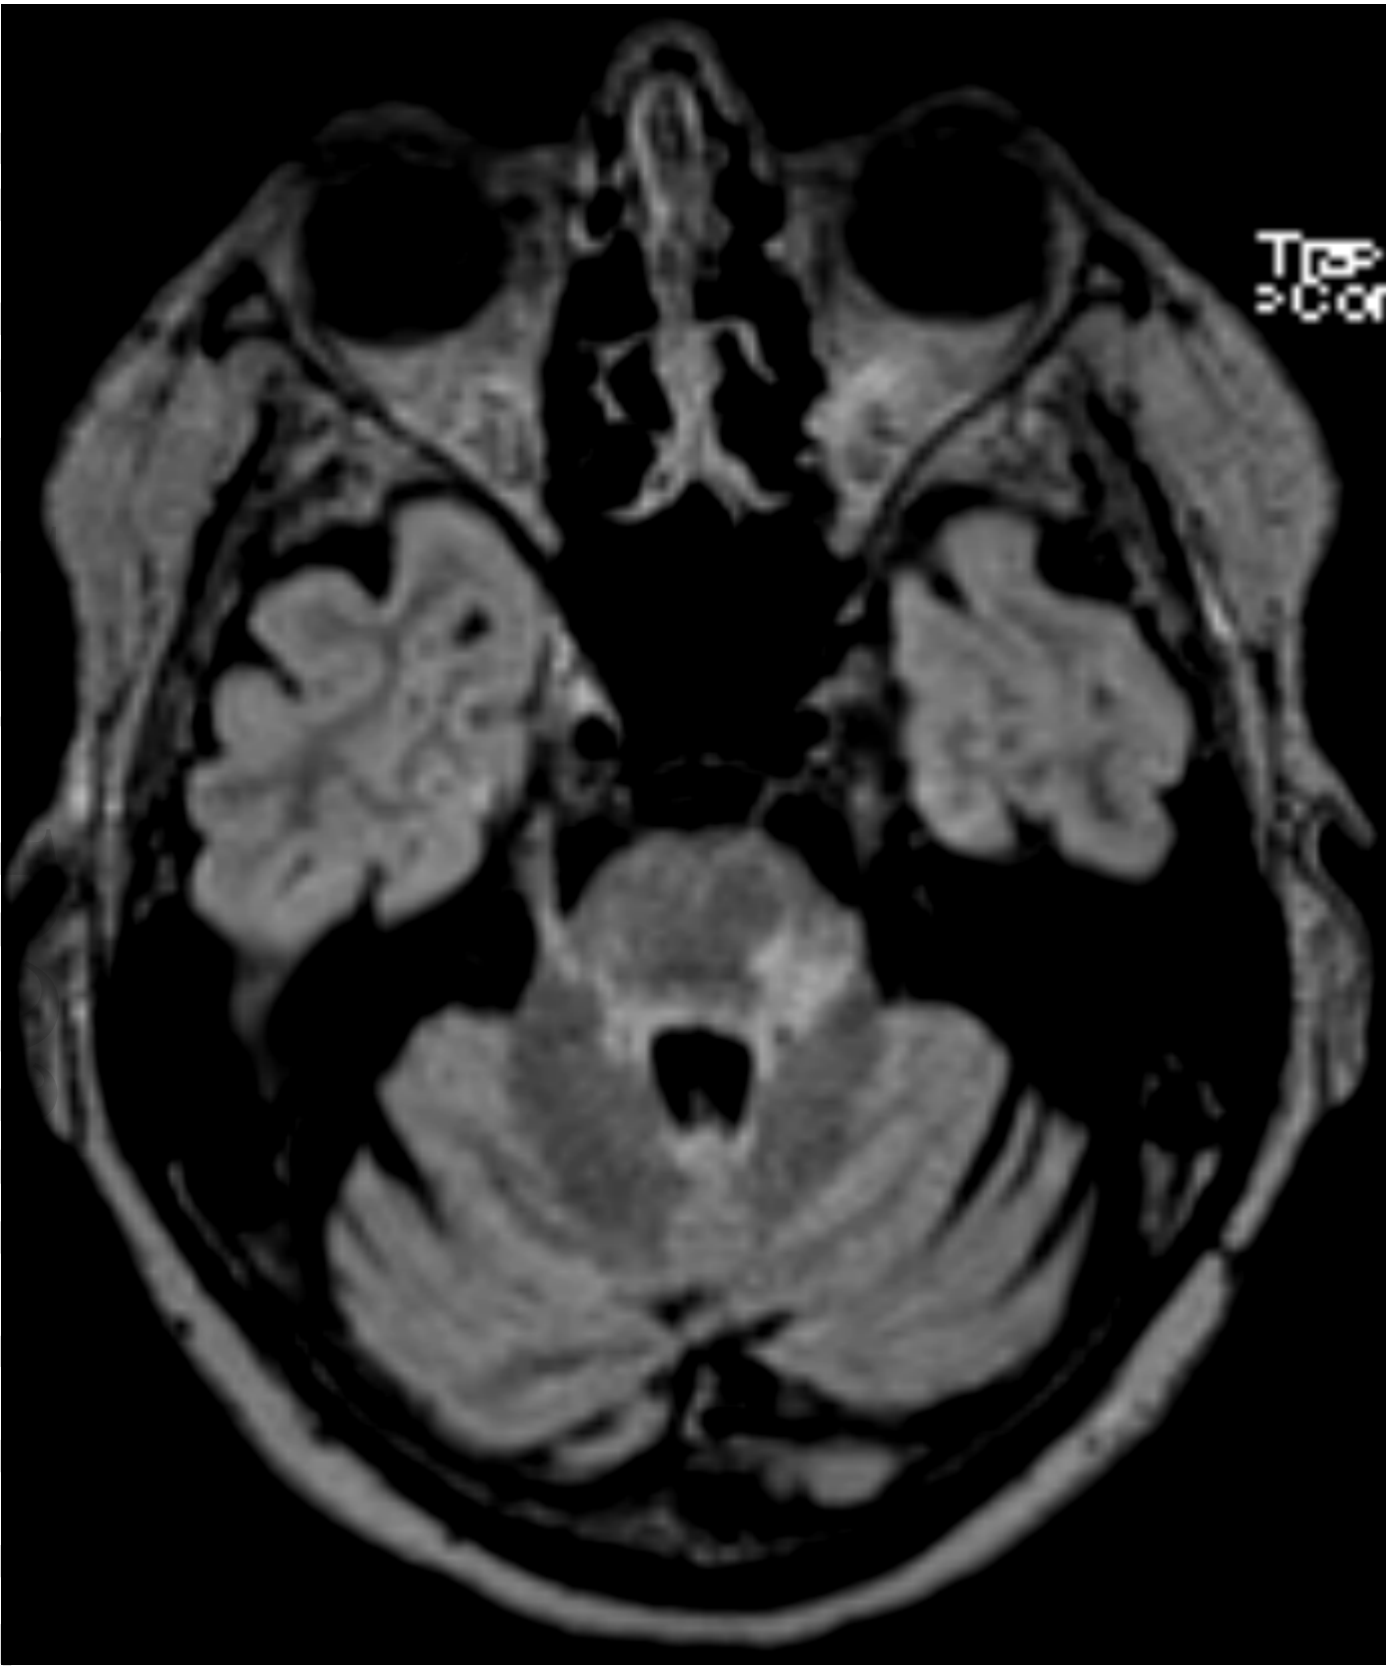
A representative MRI scan showing a demyelinating lesion near the trigeminal ganglion. A 52-year-old female patient with MS had the onset of left-sided TN at the age of 40 years. An MRI taken 10 years later, when the TN was clinically very active, showed a relatively large demyelinating lesion on the left in the pons, near the trigeminal ganglion. MRI field strength was 1.5T (T2 flair sequence).
